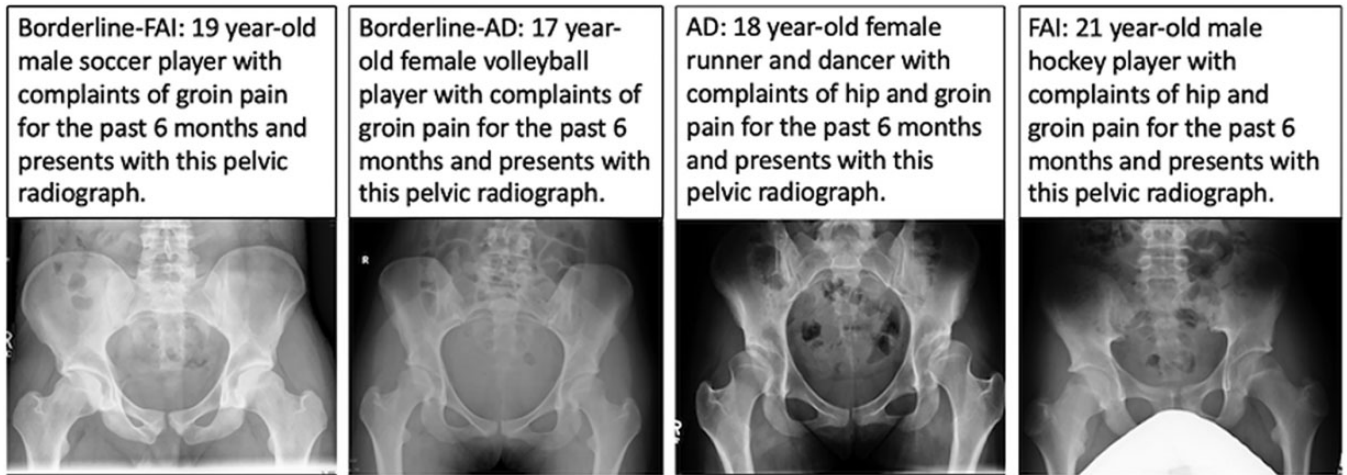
Four clinical case vignettes of nonarthritic hip pain, including a brief history and an anteroposterior pelvic radiograph. AD, acetabular dysplasia; FAI, femoroacetabular impingement.
